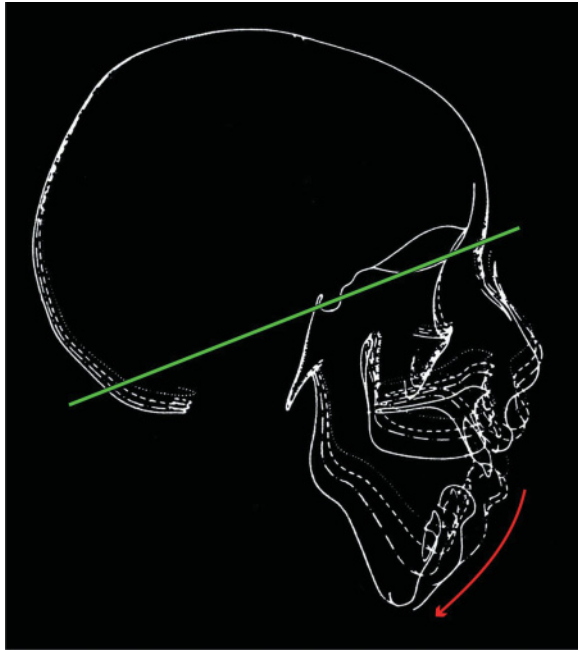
Excessive vertical facial growth pattern and posterior mandibular rotation in a patient with muscular dystrophy; cephalometric radiographs superimposed from ages 4 $\frac{3}{4}$ years, 6 $\frac{3}{4}$ years, 8 $\frac{3}{4}$ years and 12 $\frac{1}{2}$ years. (Modified from Kreiborg et al.¹⁵ with permission from Elsevier.)
